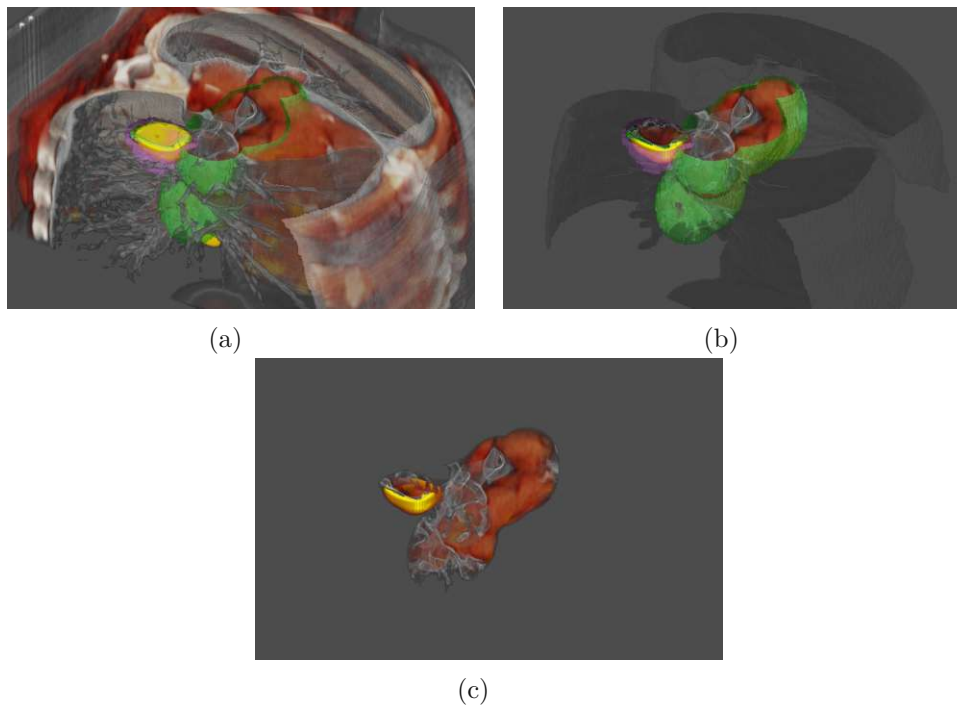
(a) Fusion of PET and CT with surface rendering of binary volumes. (b) Fusion of PET and CT with binary volume information. The different binary volumes represent either background, one modality or the fused PET and CT. (c) Same as (b) without surface rendering of binary volumes. Clipping was applied to hide parts of the thorax.
